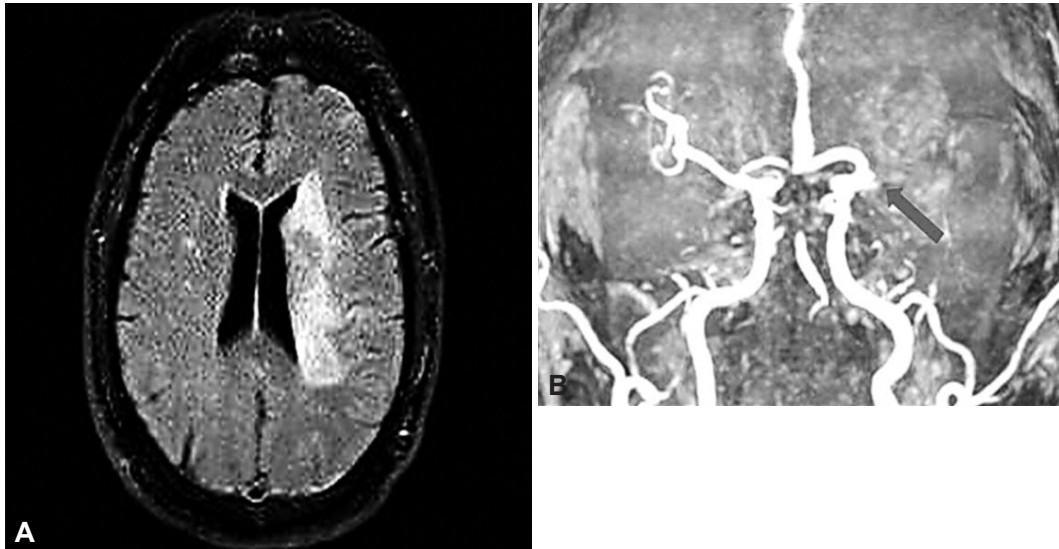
Acute large middle cerebral artery infarction shown in diffusion-weighted scan of brain magnetic resonance image (A) and magnetic resonance cerebral angiography (arrow) (B).
